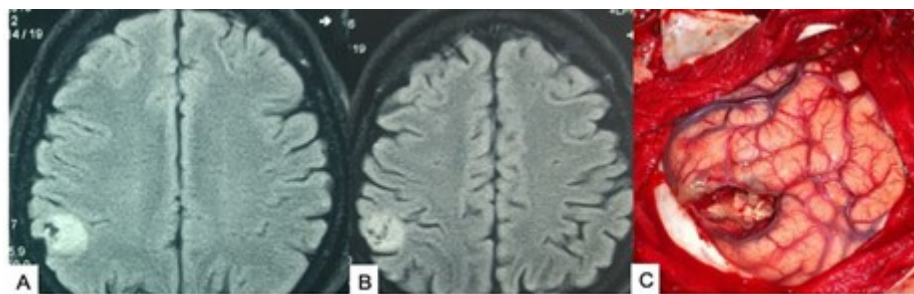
(A,B) MRI of brain showing right-sided parietal post-neurocysticercosis gliosis. (C) Peroperative picture of excision of lesion. Source: Figure by authors.
